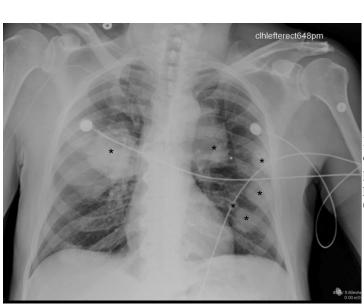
(left): 63 year old male with extraskeletal osteosarcoma. AP Chest X-ray one and half years after initial presentation shows the development of multiple large pulmonary masses, consistent with "cannonball" metastasis (asterisks).
